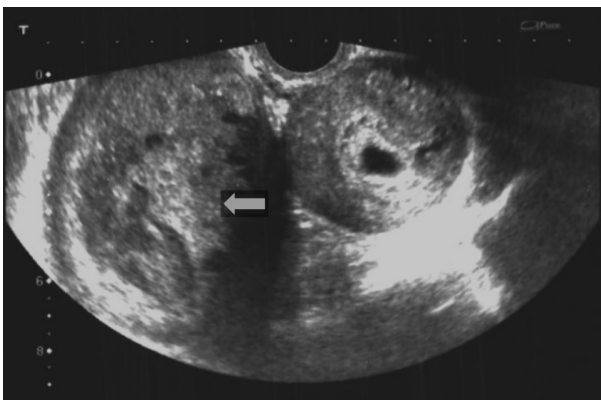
Appearance of the mass on the transvaginal ultrasound.
